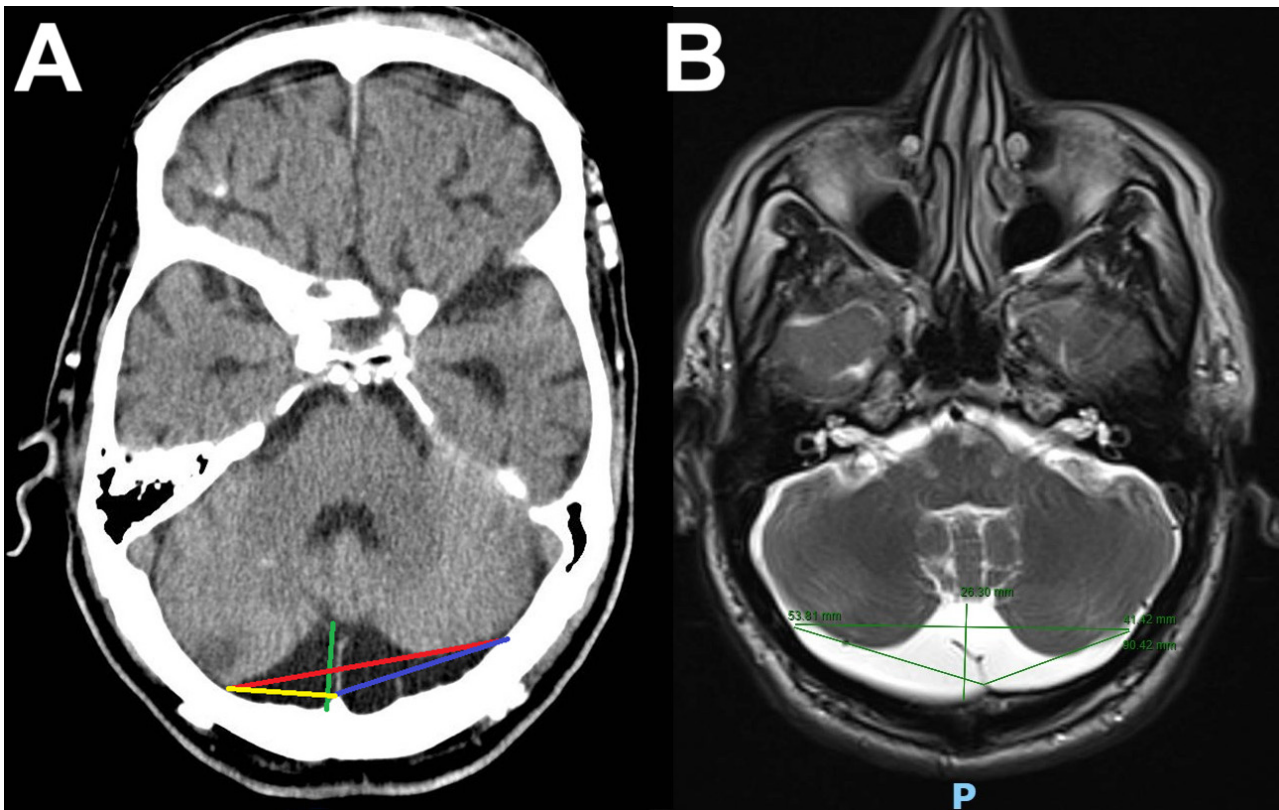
Measurements applied to the brain CT scan (A) and MRI scan (B). The green is the length, the yellow is the right wing width, the blue is the left wing width, and the red is the whole width of the MCM on the brain CT.
